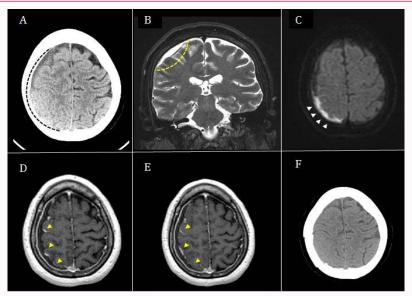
1F: A. First cranial CT. B. Axial T2 MRI. C. Axial diffusion MRI. D,E. Weighted gadolinium-enhanced MRI. F. Post surgical CT.
